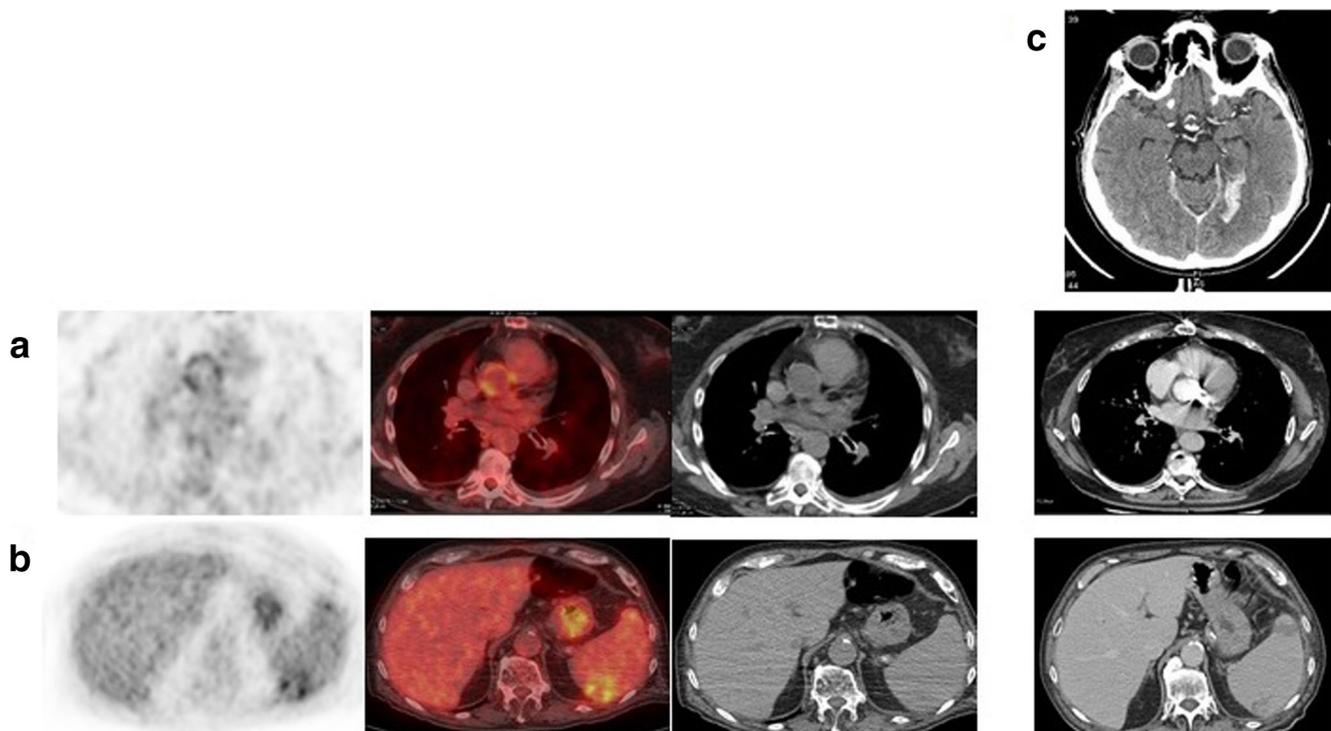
Same patient as in Fig. 5c. In addition to the diffuse uptake of mild intensity at the valve prosthesis (a from left to right transaxial emission, superimposed PET/CT, low-dose CT and ce-CT images), combined [^{18}F]FDG PET/CT with ce-CT allows the identification of spleen
